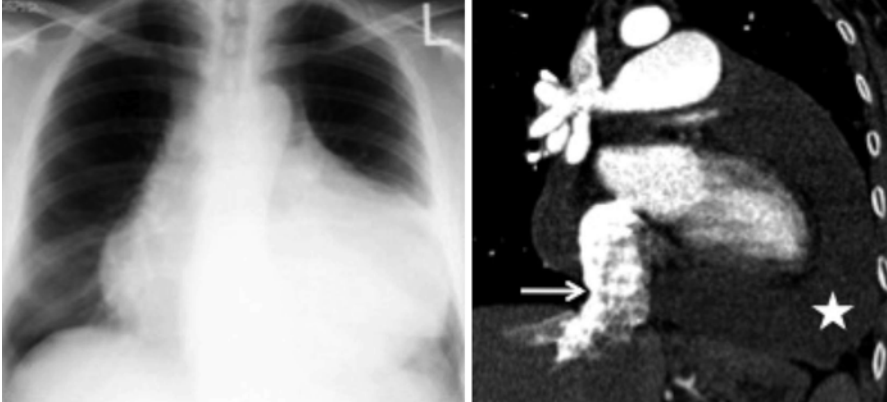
A 53-year old female with breast carcinoma presented with worsening dyspnea. The cardiac silhouette is enlarged with a globular shape on the CXR. Coronal contrast enhanced CT confirmed pericardial effusion (*white star*) that was large and circumferential with dilated systemic veins (*arrow*)
